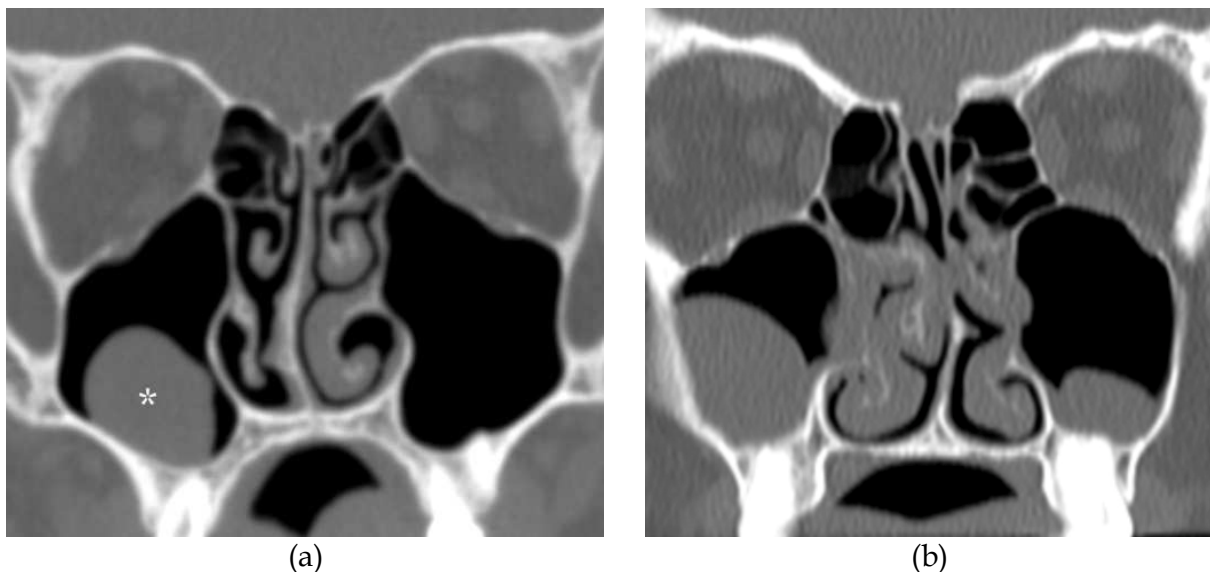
(a) Coronal CT shows a smooth, outwardly convex soft tissue mass (asterisk) originating from the maxillary floor. No underlying bone destruction or periondontic abscess are seen and the mass should be interpreted as a retention cyst. (b) Coronal CT in another patient shows retention cyst in each maxillary sinus and slight mucosal thickening/retention cyst in the right nasal cavity.
